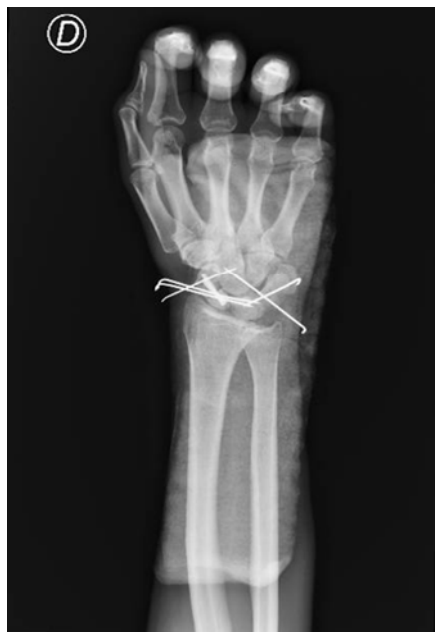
Anterior-posterior X-ray of the right hand and wrist taken immediately after surgery. Source: Image obtained while the patient was being treated.
